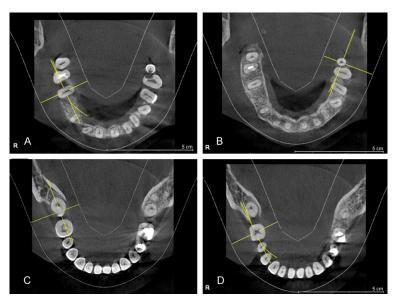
The cone-beam computed tomography image of the maxillary (A, B) and mandibular (C, D) molars in the axial section.
